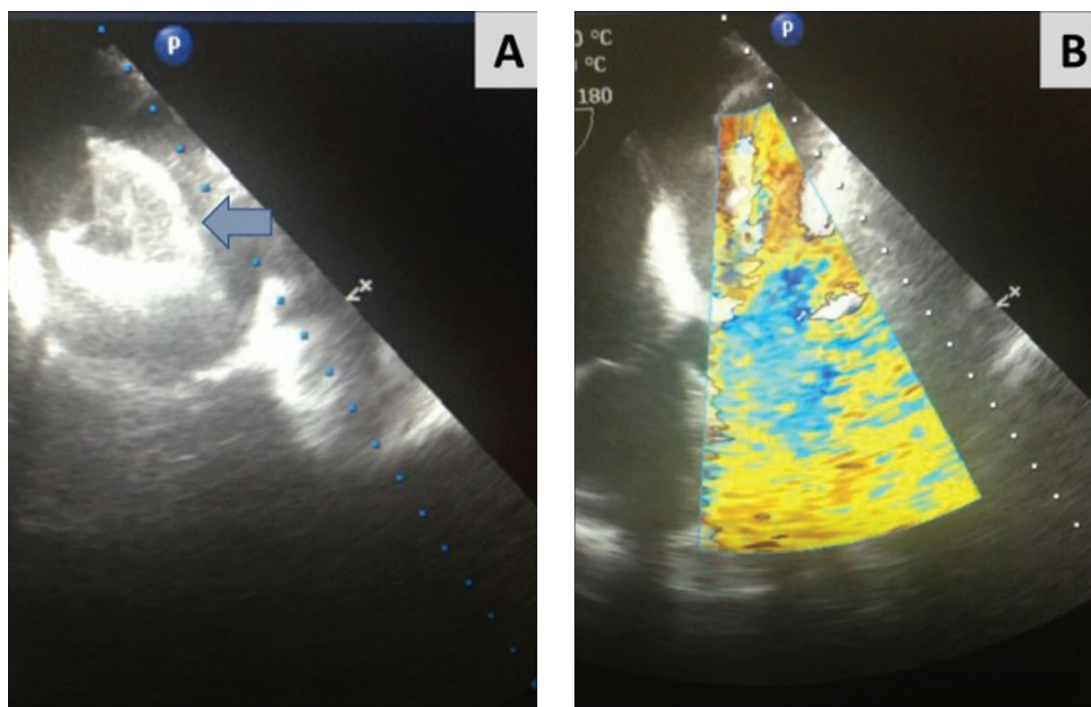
Transesophageal echocardiogram performed after hemodynamic decompensation. Images revealed a migrated MitraClip device (arrow) floating into the left atrium (panel A) and a torrential acute mitral valve regurgitation with central jet (panel B).
